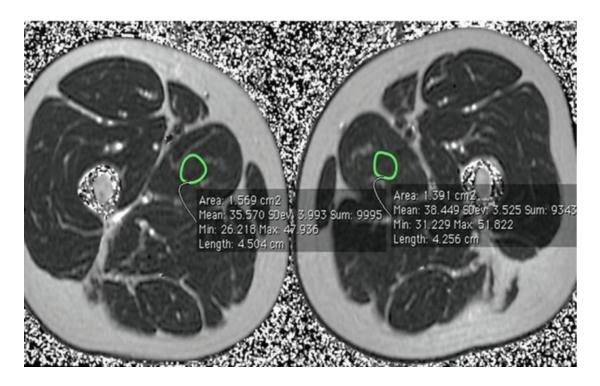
Recreational 36-year-old soccer player with an untreated complete avulsion of the left adductor longus tendon at its pubic insertion 2 months prior, demonstrated on coronal fat-suppressed T2-weighted MRI (\mathbf{a} ; arrow). The appearance of the left adductor muscle on the axial T1-weighted MRI of the left thigh is unremarkable (\mathbf{b} , arrows). Axial color T2 mapping of both thighs without exercise demonstrates multiple foci of increased T2 values within the left adductor muscle compared with the right side (\mathbf{c} , arrows), possibly indicating early fat atrophy of the left adductor longus muscle. Quantitative assessment of T2 values (\mathbf{d}) of both adductor muscles shows a higher T2 value on the left side than on the right (38.45 ms \pm 3.52 vs. 35.57 ms \pm 3.99)
